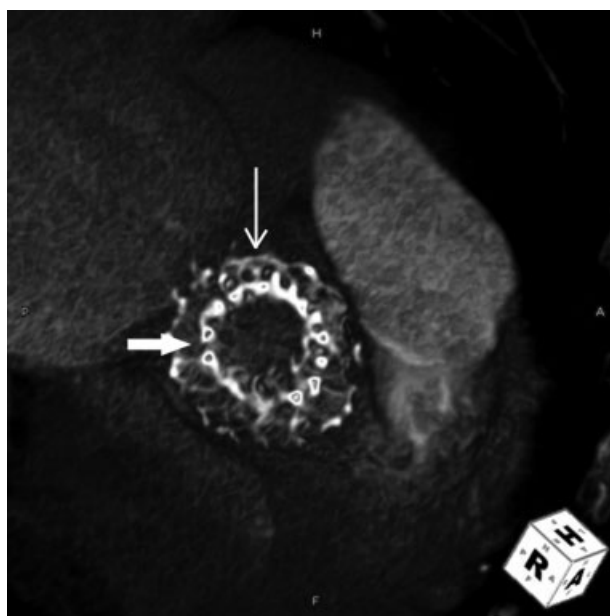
CTA (axial view) demonstrating CoreValve-in-Core-Valve prostheses.
